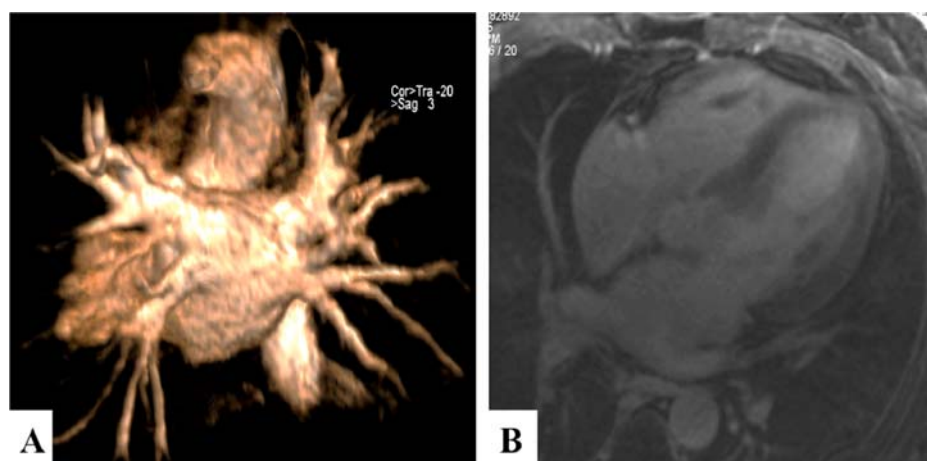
Magnetic resonance imaging of a 50 year old male patient presenting in Aswan Heart Centre before pulmonary vein isolation procedure for recurrent symptomatic paroxysmal AF despite being on Class III antiarrhythmic. (A) 3D reconstructing of magnetic resonance pulmonary veins angiography (PA view) demonstrating the site of entry of each pulmonary vein. (B) 2D delayed contrast hyperenhancement demonstrating no fibrosis of left atrium tissue.
